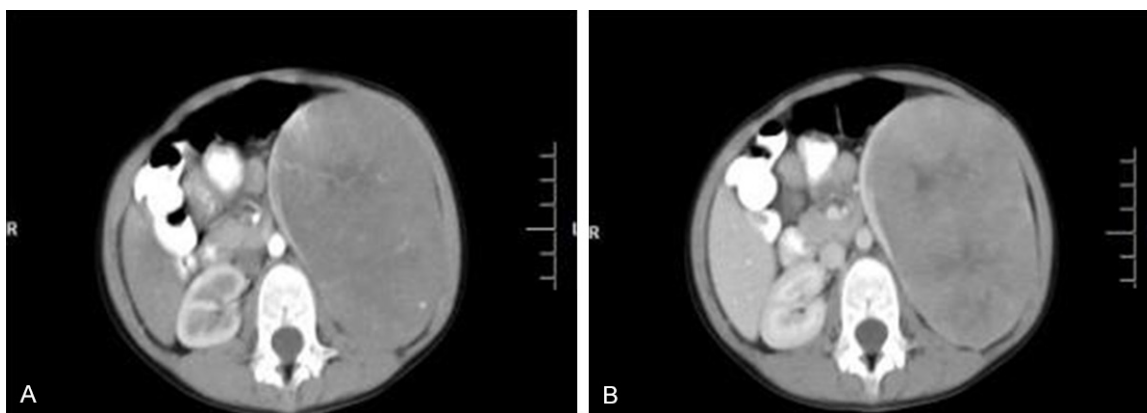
CT enhanced scan: A. Arterial phase CT scan. B. Venous phase CT scan. CT scan showed that there was a large soft tissue mass with uneven density in the parenchyma of the left kidney and small flaky low-density areas with necrotic cystic degeneration. After contrast-enhanced scan, there was slight uneven enhancement in the arterial phase, and continuous and progressive enhancement in the venous phase.
